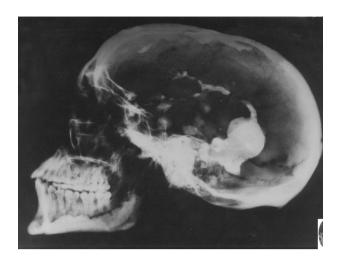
Lateral X-ray of the skull. The sella turcica is on display, showing a considerable width, it is protected by the clinoid processes.
